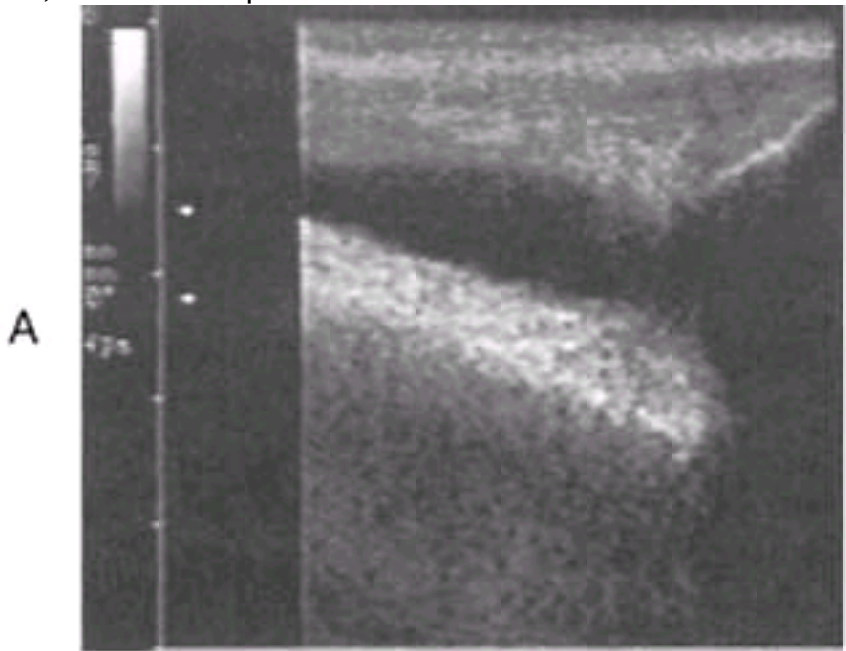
Sonographic appearance of peritoneal free fluid. Fluid will appear as a large anechoic area with loops of bowel floating freely. The optimal area for needle insertion is where there is a large pocket of fluid just under the skin surface, closest to the probe.
